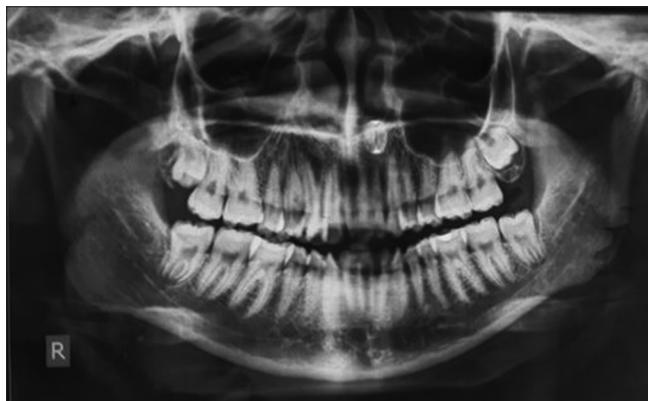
Case 2 pretreatment orthopantomogram
